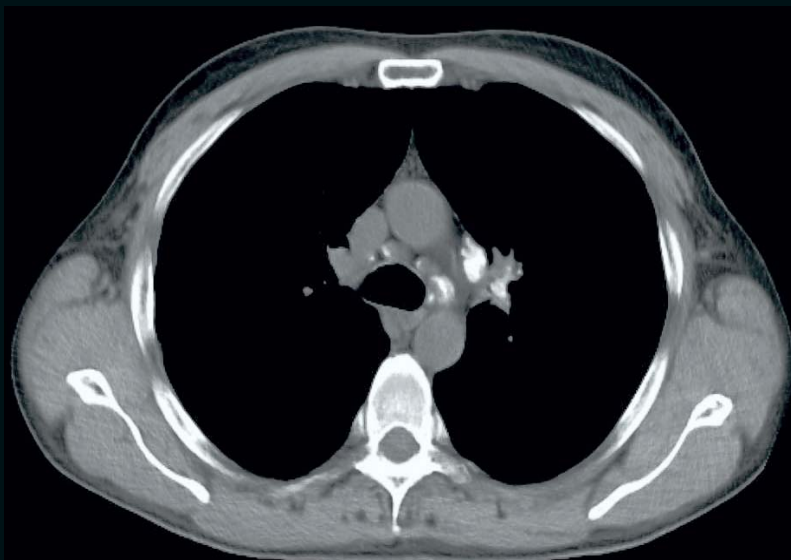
Chest CT re-examination after 6 months: Multiple hilar and mediastinal bilateral lymphadenopathies, with stable size
